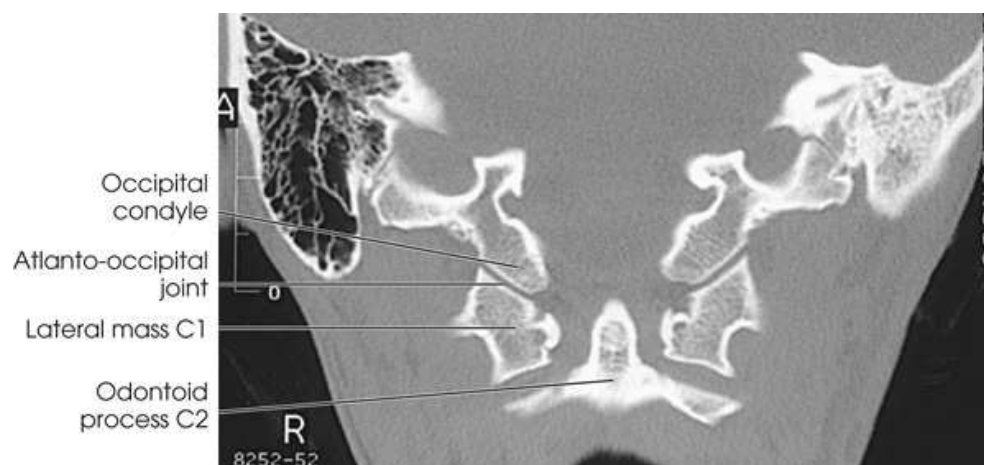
Coronal MRI shows atlas, axis, and occipital bone of skull and their relationship. Courtesy Siemens Medical Systems, Iselin, NJ.
